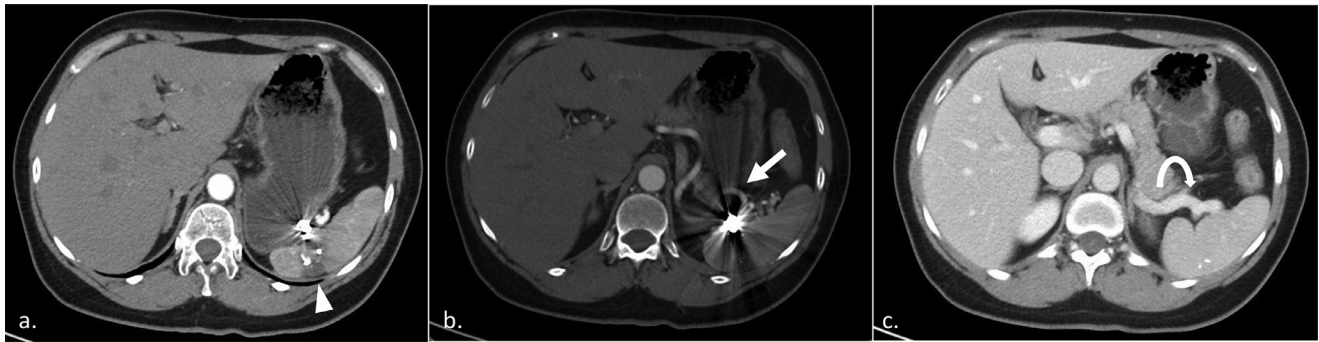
CT of the abdomen in arterial phase demonstrates a small infarct of the spleen (arrowhead) (A). The splenic artery (arrow) and vein (curved arrow) have decreased in size after coiling (B and C).
